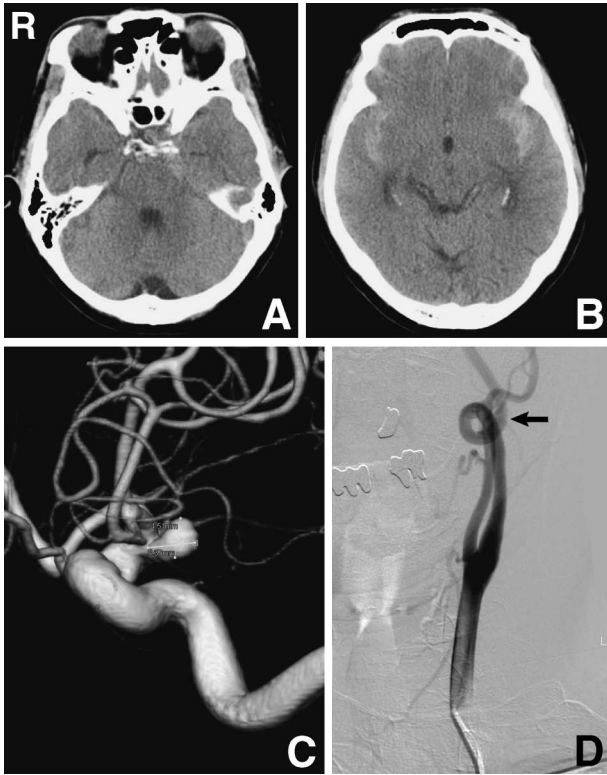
A, B: Computed tomography scans on admission showing subarachnoid hemorrhage. C: Three-dimensional digital subtraction angiogram revealing an anterior choroidal artery aneurysm. D: Left common carotid angiogram showing coiling of the extracranial internal carotid artery (arrow).
